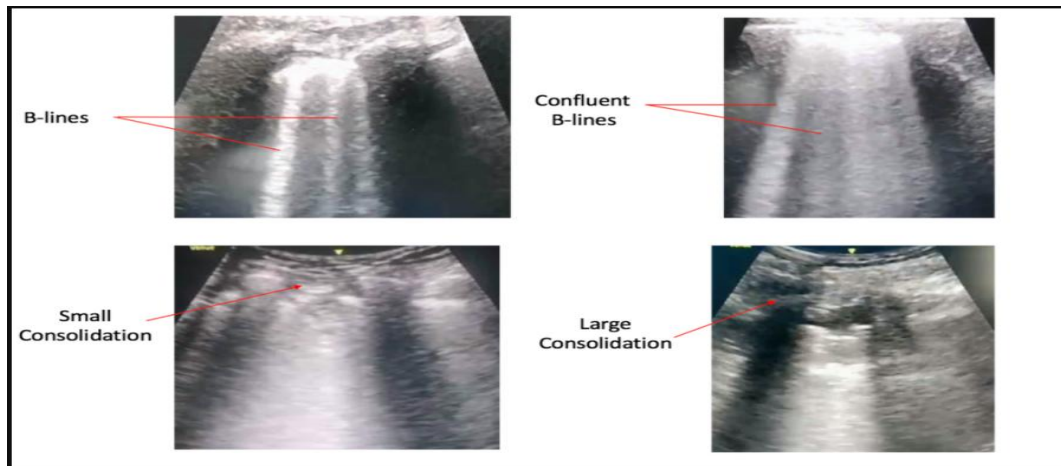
Lung ultrasound findings in patients with COVID-19 infection
